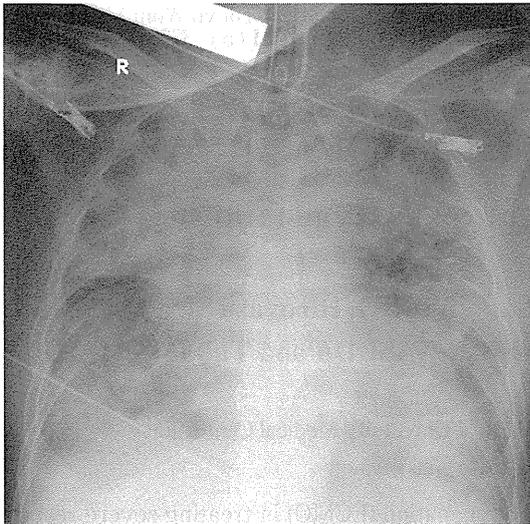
Chest X-ray film on arrival
